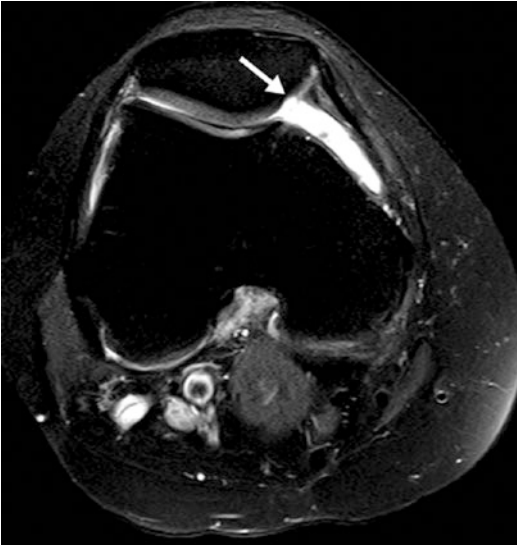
Fat-suppressed proton density-weighted axial MR image shows focal articular cartilage defect in the medial patella (arrow)
